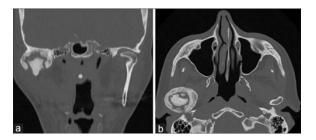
(a) Preoperative computed tomography scan coronal view. (b) Preoperative computed tomography scan axial view
